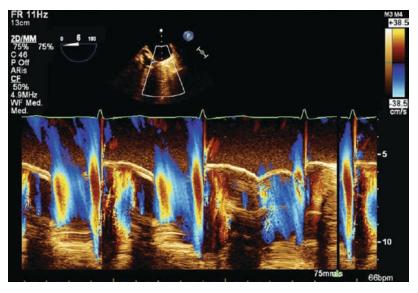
Color Doppler imaging. *Blue* away from and *red* toward the transducer
